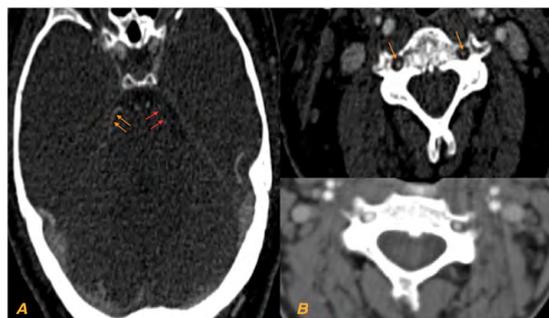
CT angiogram (A) showing narrowed right posterior cerebral artery (arrowheads) and non-visible left posterior cerebral (red arrowheads), CT angiogram (B) showing the patient's bilateral stenosed vertebral arteries at C4 level (Top) compared to normal looking arteries at similar level (bottom).
